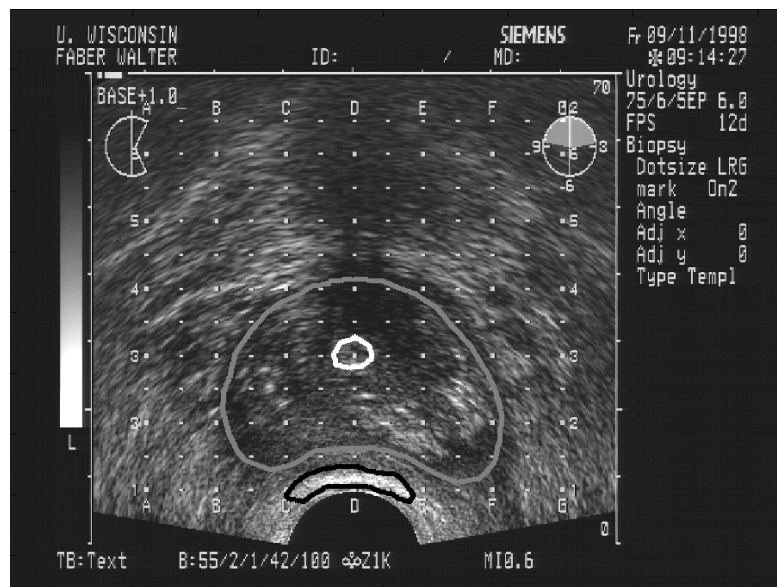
TransRectal Ultrasound image of the prostate with the regions-of-interest contoured. The gray contour indicates the prostate, the white the urethra, and the black the rectum
